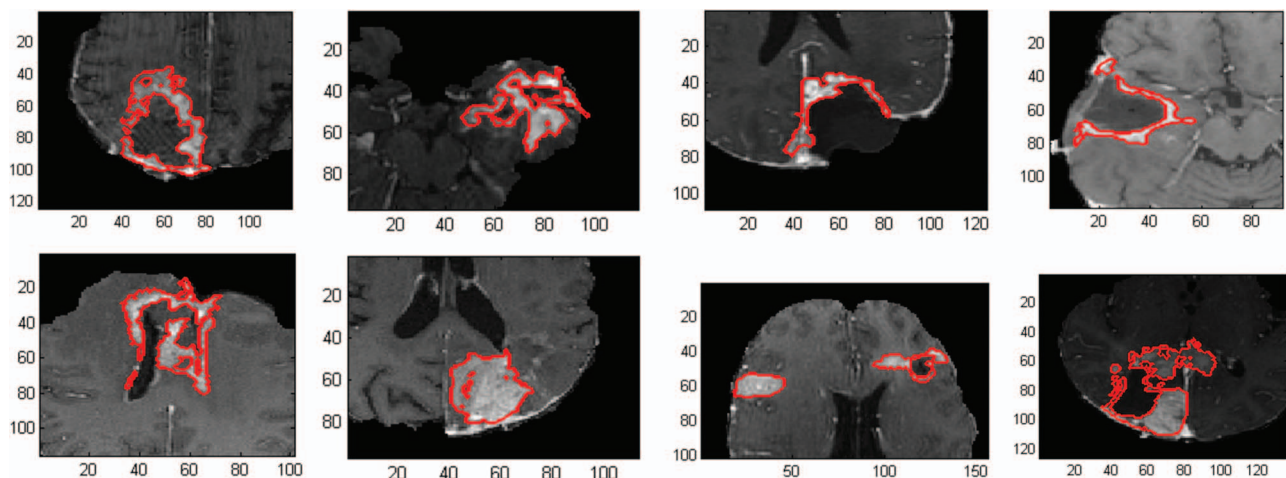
Examples of recurrent GBM tumors on MR images. The contours show the doctor's reading.
